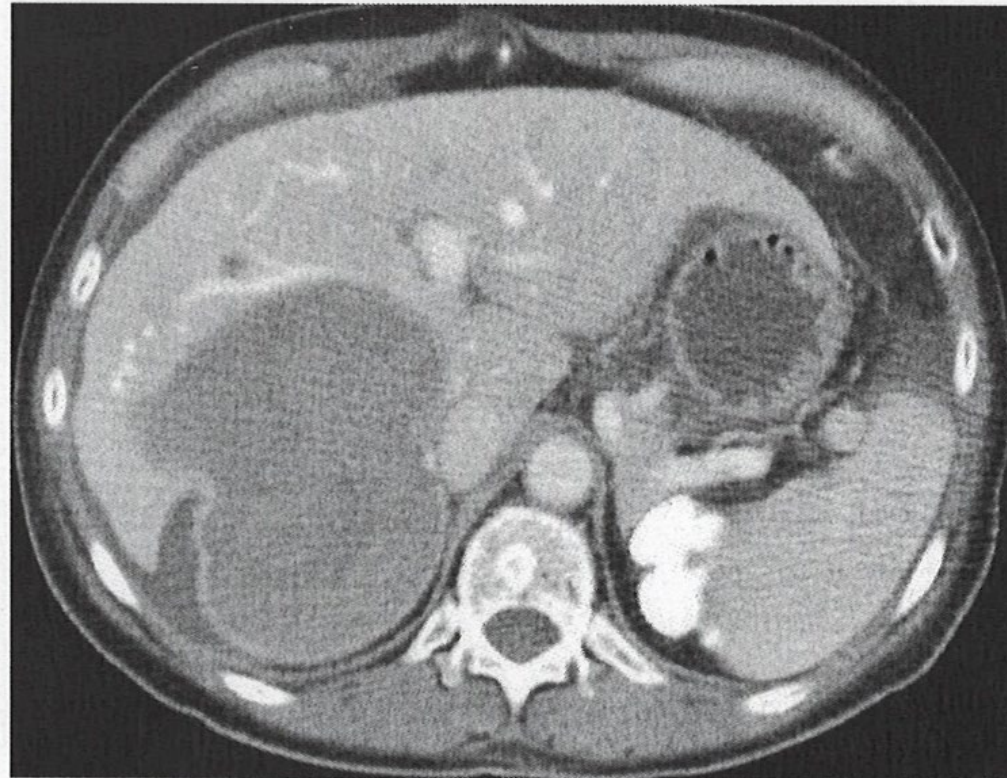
CT Abdomen with IV and oral contrast.
